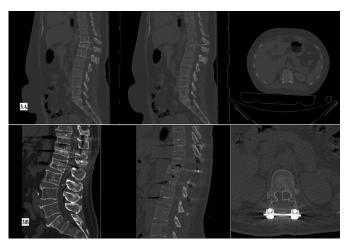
The pictures show no instability in the postoperative long-term follow-up X-ray images of a patient who underwent short-segment instrumentation, and the instrument's structural integrity is preserved
